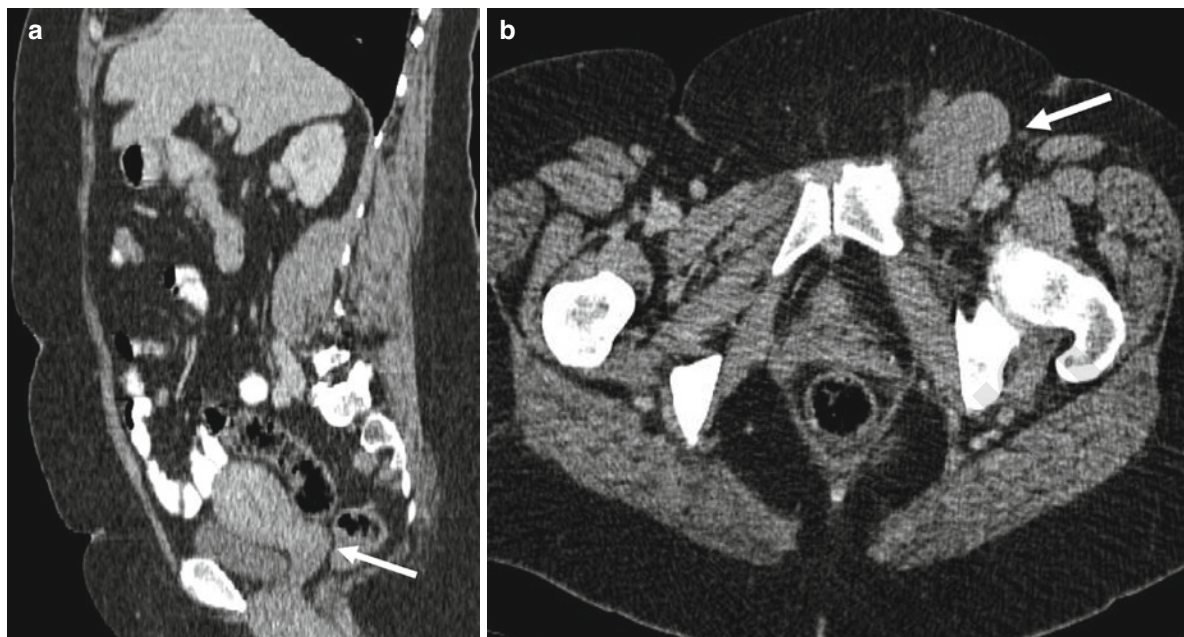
(a) CT small cell cervical cancer with small primary tumour bulk (*arrow*) and minimal parametrial extension but, (b) bulky inguinal adenopathy (*arrow*)
